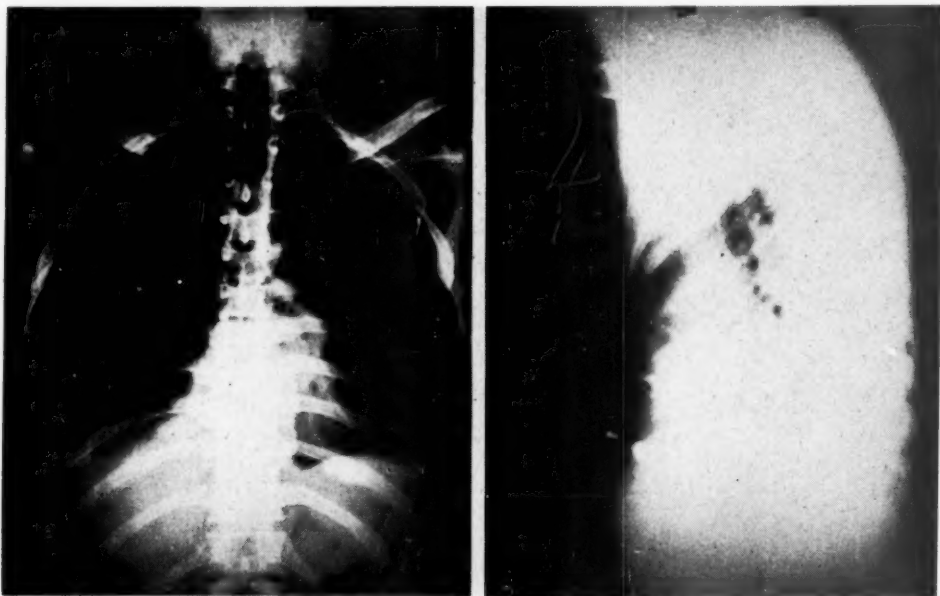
Posteroanterior and lateral roentgenograms demonstrating the original position of the fragment in the right ventricle.
